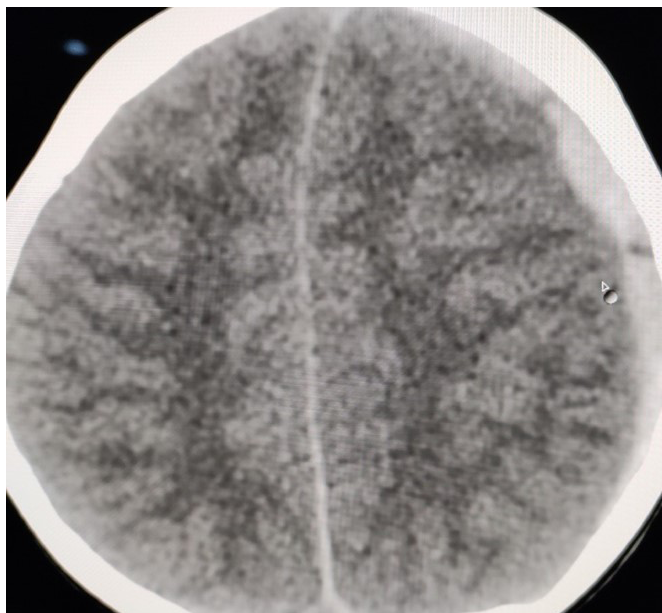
Computed Tomography of brain showing left sided extradural hemorrhage.
